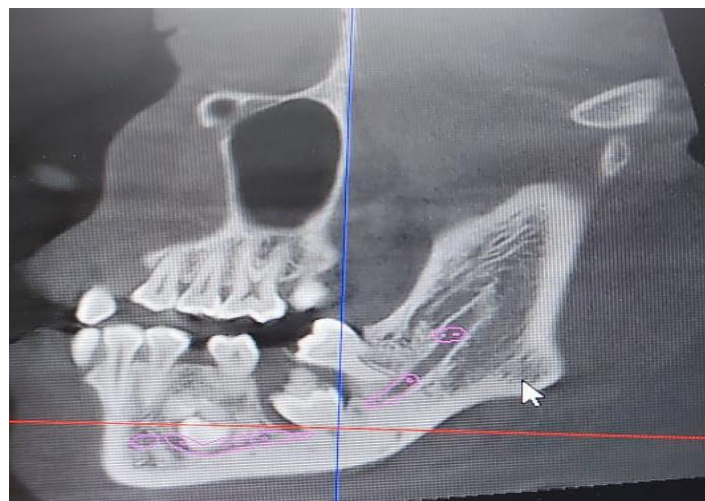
[b] Sagittal sections of computed tomography depicting unilateral multiple small and large nonspecific, disorganised, irregular radio-opaque mass with varying densities
